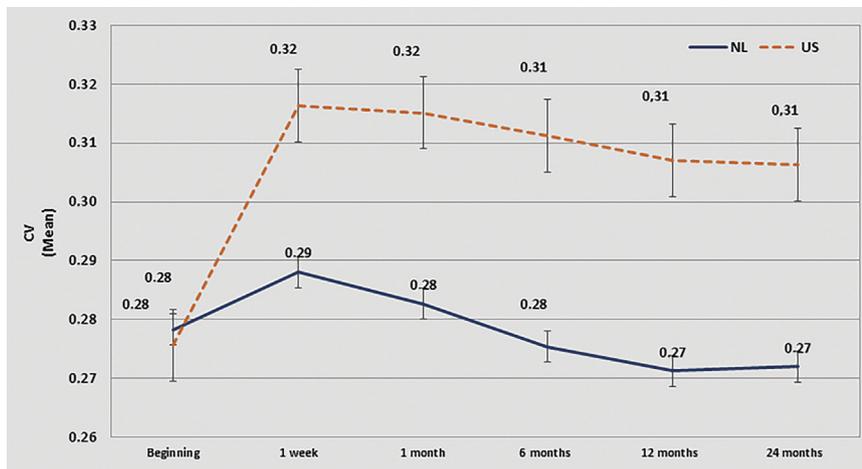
The mean CoV over a 24-month period ($P < .001$) (CV = coefficient of variation; NL = nanosecond laser; US = ultrasound).
